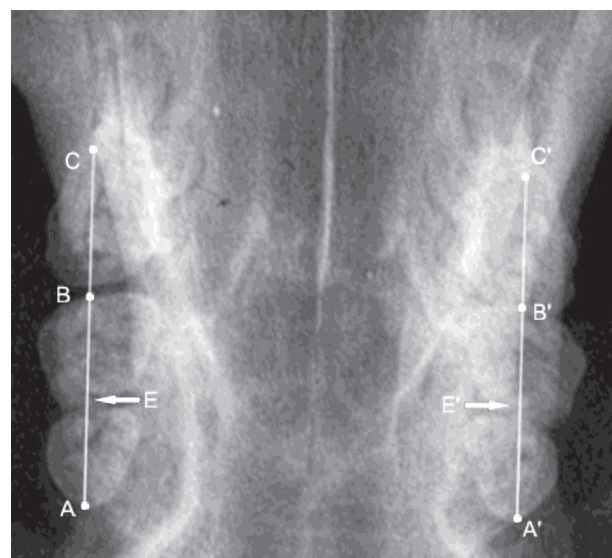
Landmarks and E line on the special dorsoventral radiograph.
